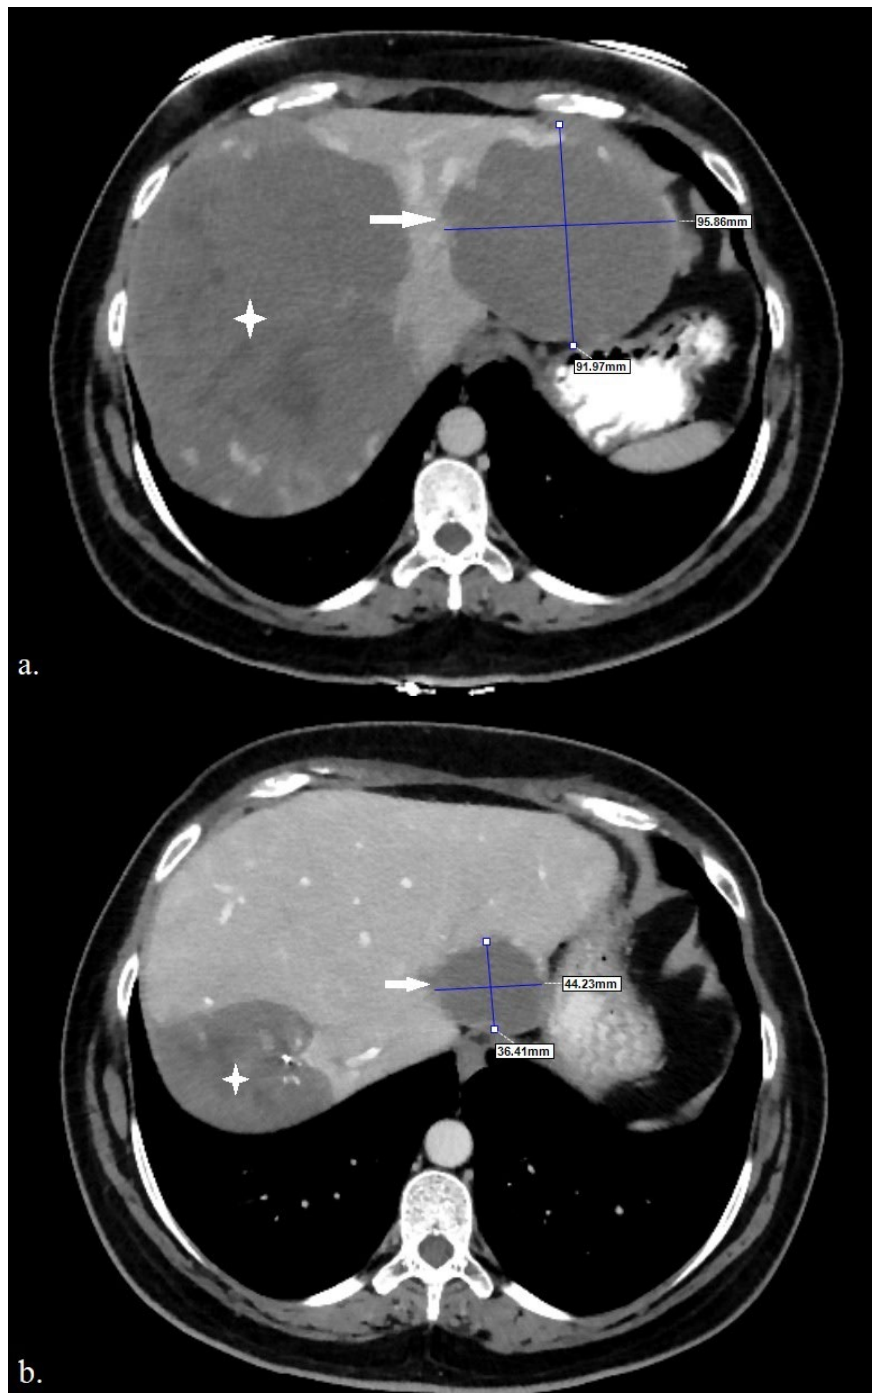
(a) Preprocedural contrast-enhanced abdominal computed tomography (CT) image of a 42-year-old female patient presenting with right upper quadrant fullness and dyspepsia, demonstrating both a target hepatic hemangioma (quadrilateral star) and a concomitant non-target hemangioma (white arrow). (b) Contrast-enhanced CT image obtained 36 months after treatment, demonstrating marked volumetric reduction of both the target lesion (quadrilateral star) and the non-target hemangioma (white arrow) following bleomycin-lipiodol transarterial chemoembolization.
